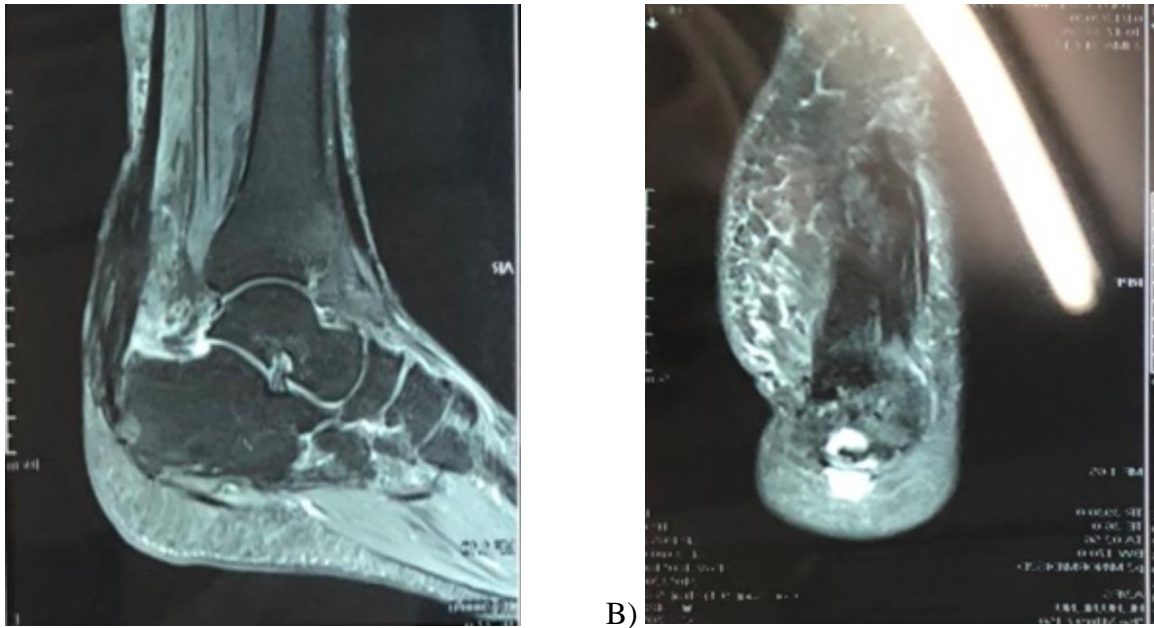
MRI of the left foot after VAC therapy.
